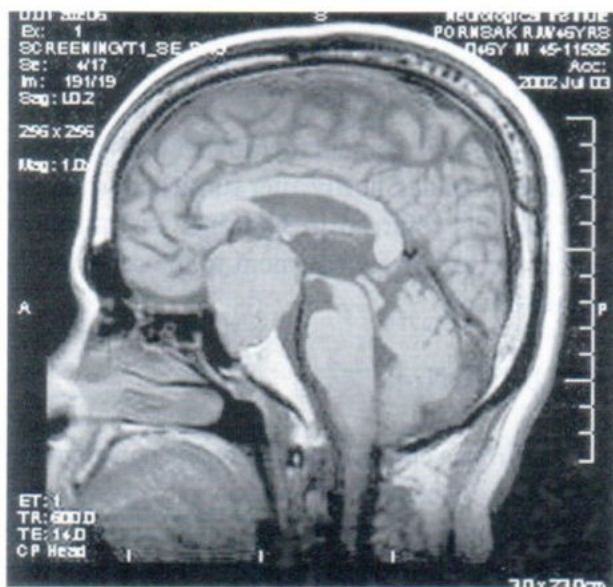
MRI sagittal SE T1 (TR/TE 600/14) in midline slice and Fig 5 axial FSE T2W (TR/TE 3300/58) show a large sellar-suprasellar mass of relatively hypointense to gray matter on T1W and heterogeneous hyperintensity signal on T2W. The normal posterior pituitary bright spot is absent. The pituitary stalk could not be identified as the tumor size is large. Also noted on T2WI, there are prominent vascular signal void structures around the mass.
